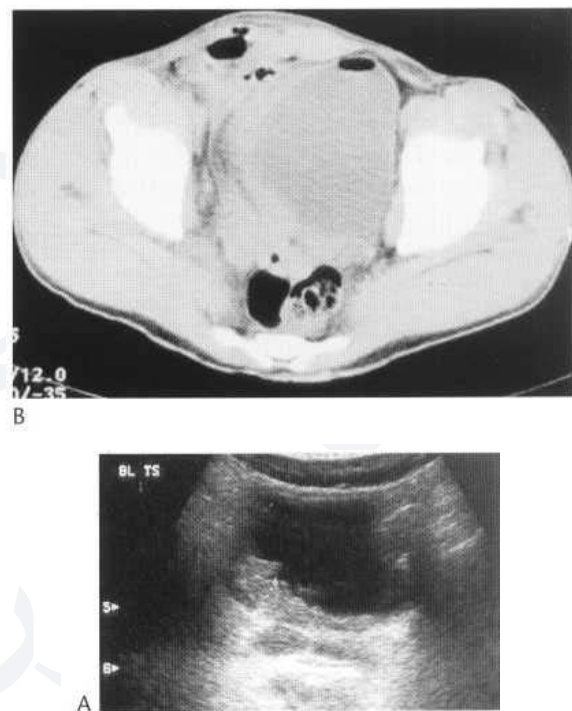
Transverse ultrasound image (A) showing gross focal thickening of the right posterolateral bladder wall in a patient with acute Crohn's disease. Similar features are seen on CT (B), which also shows adherent swollen small bowel. An enterovesical fistula is present with gas seen in the bladder.
